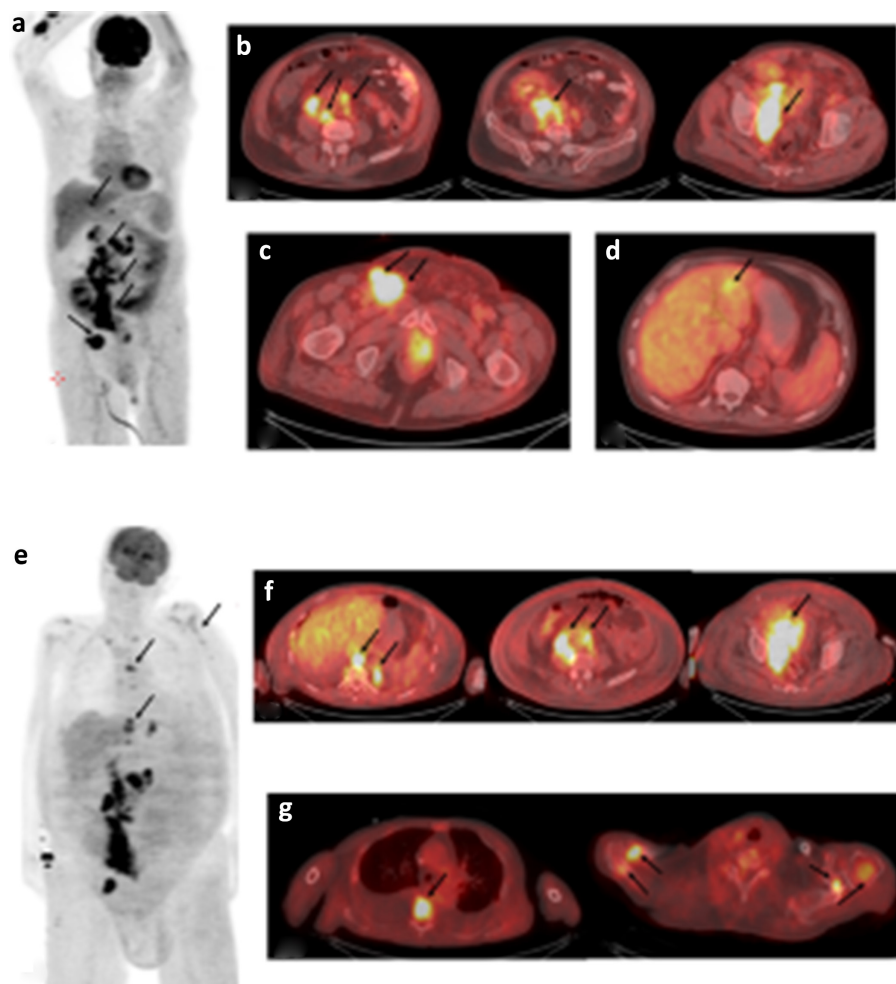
Follow-up following therapy. (a–d) Control FDG PET/CT carried out following adjuvant radiation therapy, 7 months after first presentation. High FDG uptake in the abdominal-pelvic lymph nodes and right inguinal lymph nodes was seen and there was additional focal FDG uptake in the left lobe of the liver. (Fig 2e–g). Follow-up FDG PET/CT following six cycles of chemotherapy with carboplatin and etoposide. FDG uptake in the abdominal-pelvic lymph nodes was now higher and additional bone/bone marrow metastases were determined.
